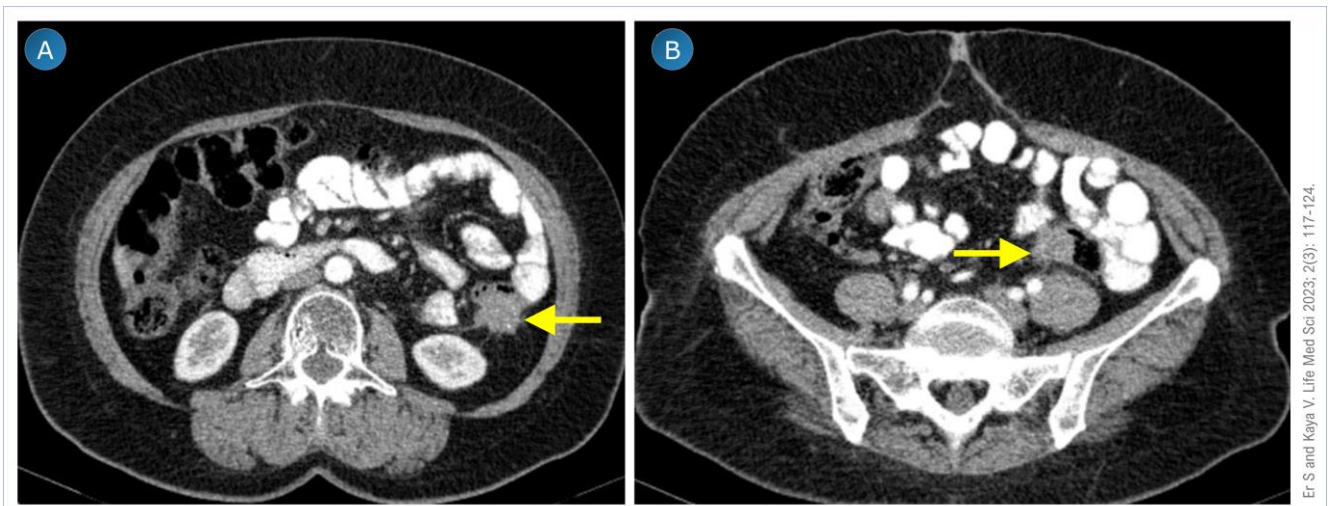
Computed tomography (CT) images of a 64-year-old man with splenic flexure tumor and serosal implant. Abdominal CT images show (A) mass infiltrating pericolic adipose tissue in the splenic flexure (arrow), and (B) serosal implant adjacent to the sigmoid colon (arrow).
